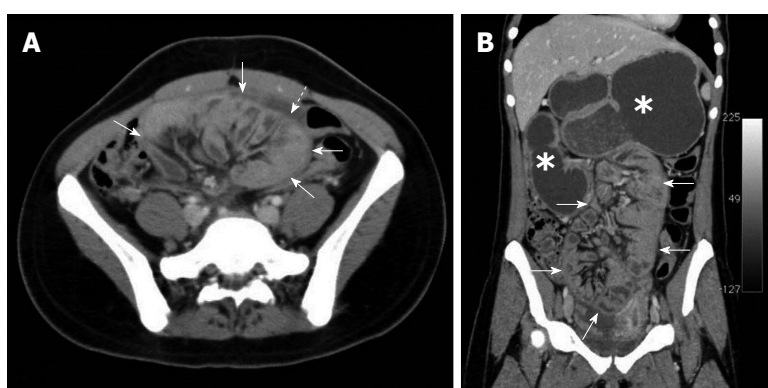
Contrast-enhanced abdominal computed tomography^[24]. Small intestinal loops are encased in a sac of thick peritoneal membrane (continuous arrows) with a small volume of peritoneal liquid effusion (discontinuous arrow). Gastroduodenal distension is also present (asterisks). A: Axial slice; B: Multiplanar coronal reconstruction.
